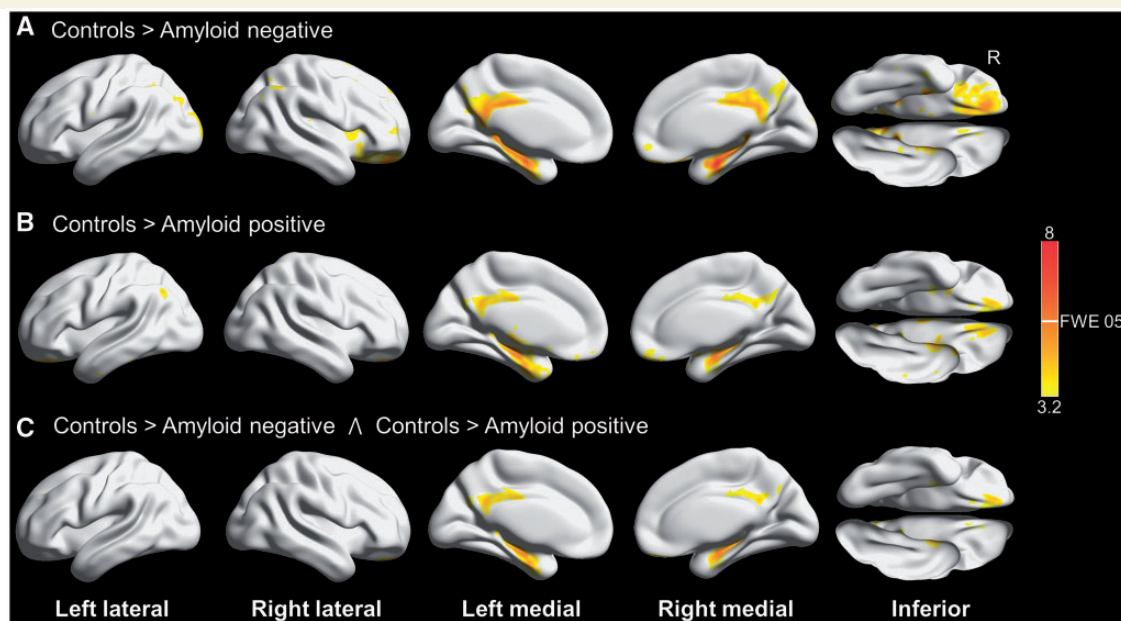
3D brain renderings showing results of FDG-PET analysis in tau-negative patients. Results are shown at $P(\text{unc}) = 0.001$ with the height cut-off for family-wise error (FWE) correction shown in the colour bar. (A) Compared to controls, tau-negative amyloid-negative participants had hypometabolism in the posterior and middle cingulate and the medial temporal lobes. (B) Compared to controls, tau-negative amyloid-positive participants also had hypometabolism in the posterior and middle cingulate and the medial temporal lobes. (C) Conjunction analysis of A and B revealing areas involved in both amyloid-positive and amyloid-negative cases compared to controls. Renders created using Brain Net Viewer (Xia *et al.*, 2013) (<https://www.nitrc.org/projects/bnv/>).
